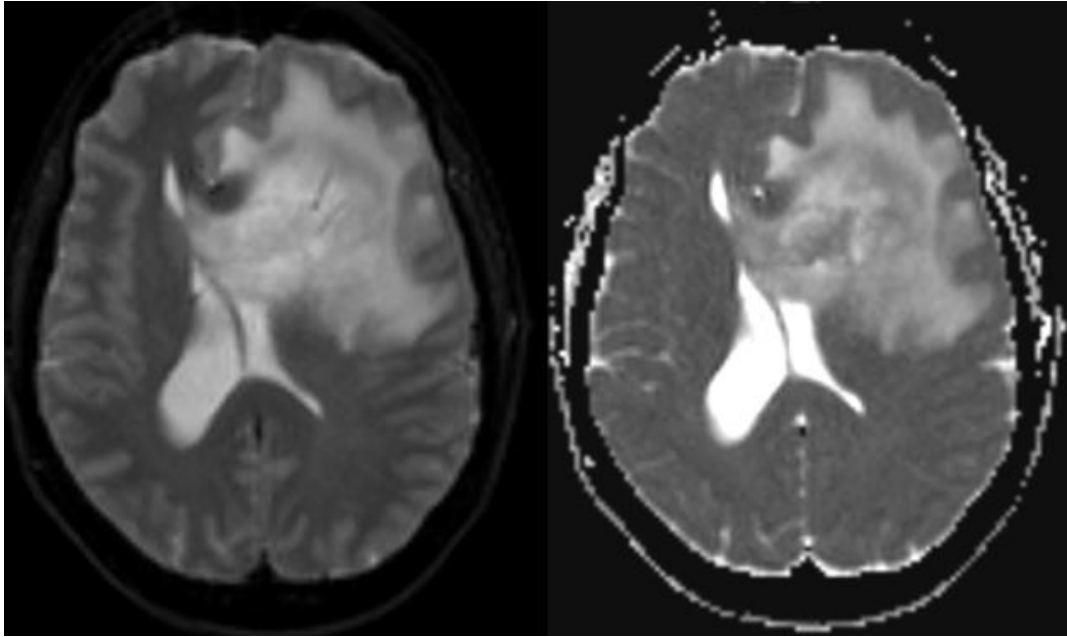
diffusion-weighted MRI GBM.
